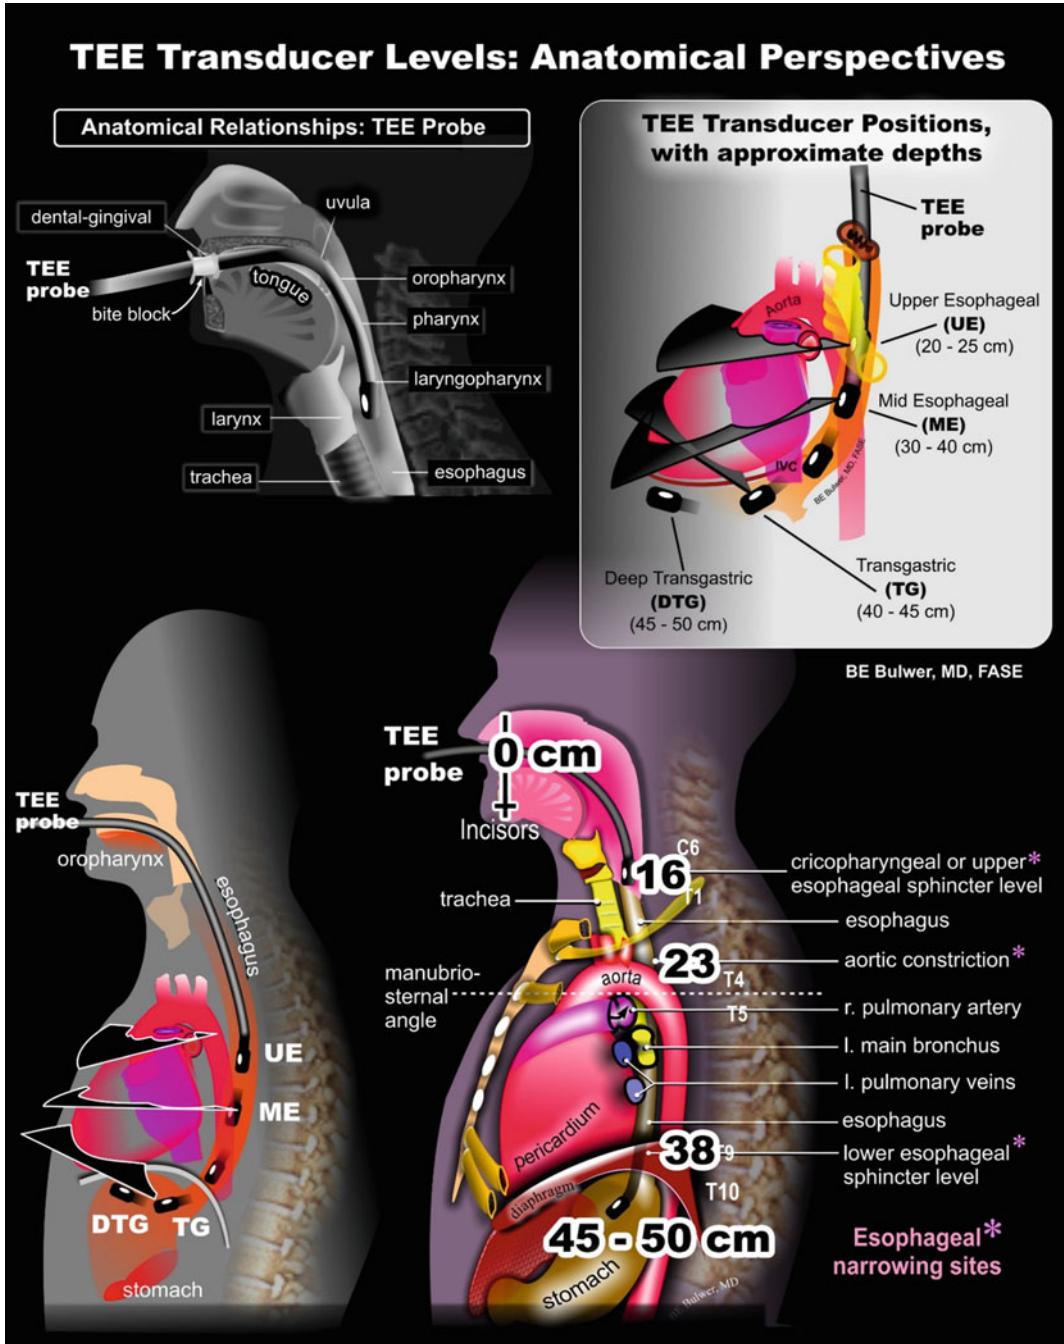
Left lateral erect perspective of the approximate transesophageal echocardiographic (TEE) transducer positions and levels in an average adult male.
